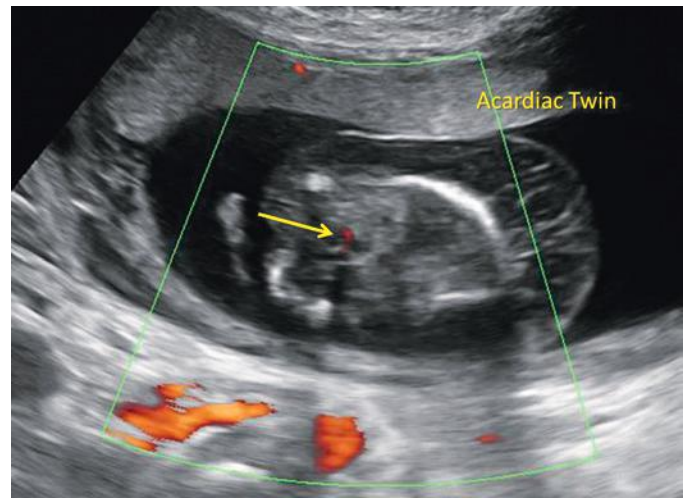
Power Doppler ultrasound image demonstrating signal, indicating flow, at the level of the umbilical cord insertion (*arrow*), but no flow was seen within the chest of this acardiac twin.
